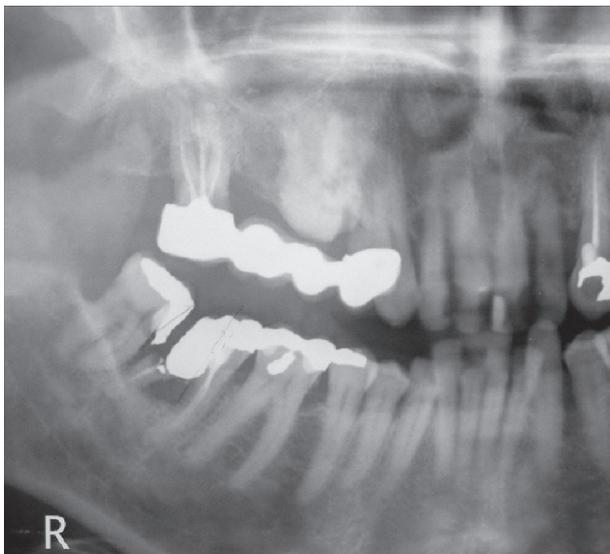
The panoramic radiograph shows a dense radiopaque mass.
